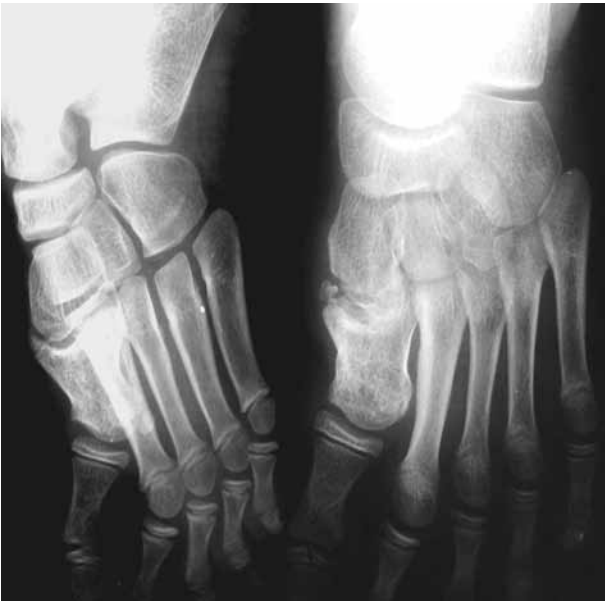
Radiograph of the right foot after 7 years follow-up showing filling of the tumour cavity with no evidence of local recurrence but with premature closure of the growth plate responsible for shortening of the first metatarsal.
